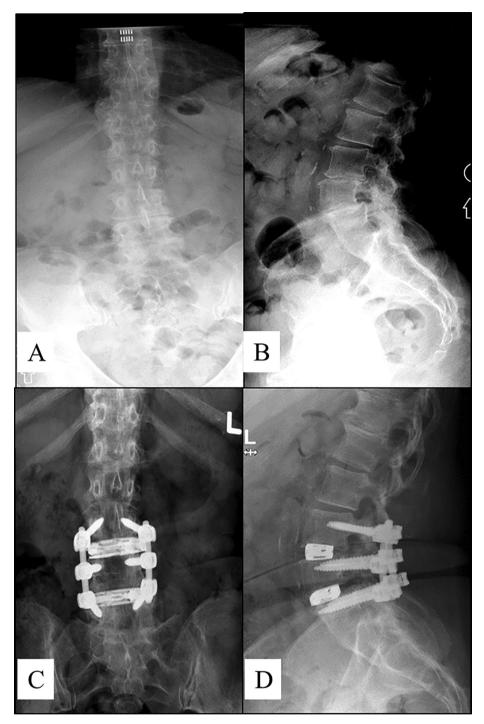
Preoperative anteroposterior (AP) (A) and lateral (B) radiographs and postoperative AP (C) and lateral (D) of a 2 L MIS-LLIF at L3/L4 and L4/L5.
